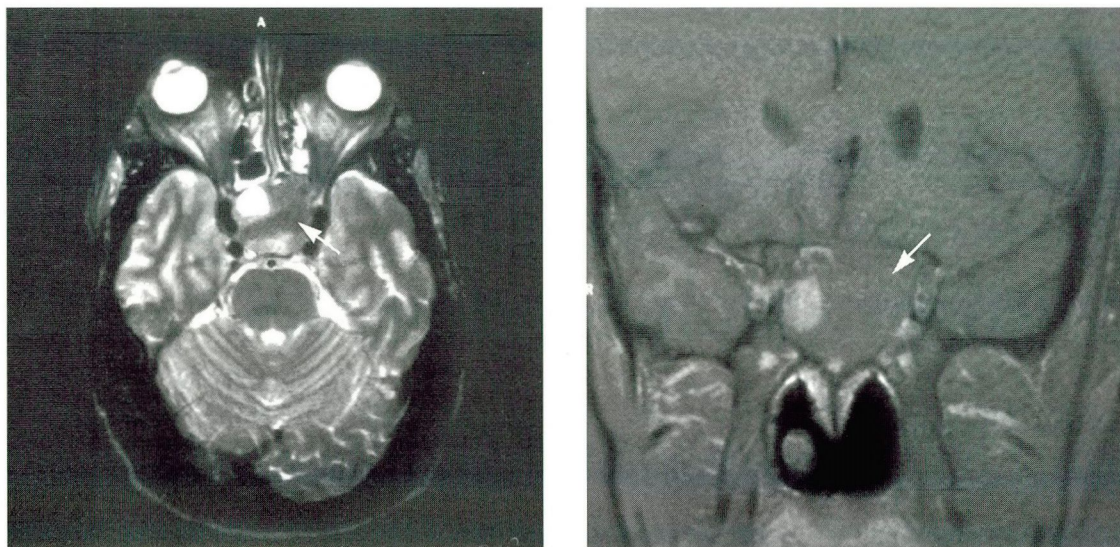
MRI examination of the brain. Left, axial section. Right, frontal section. Arrows point to a pituitary adenoma measuring approximately 4 cm.
